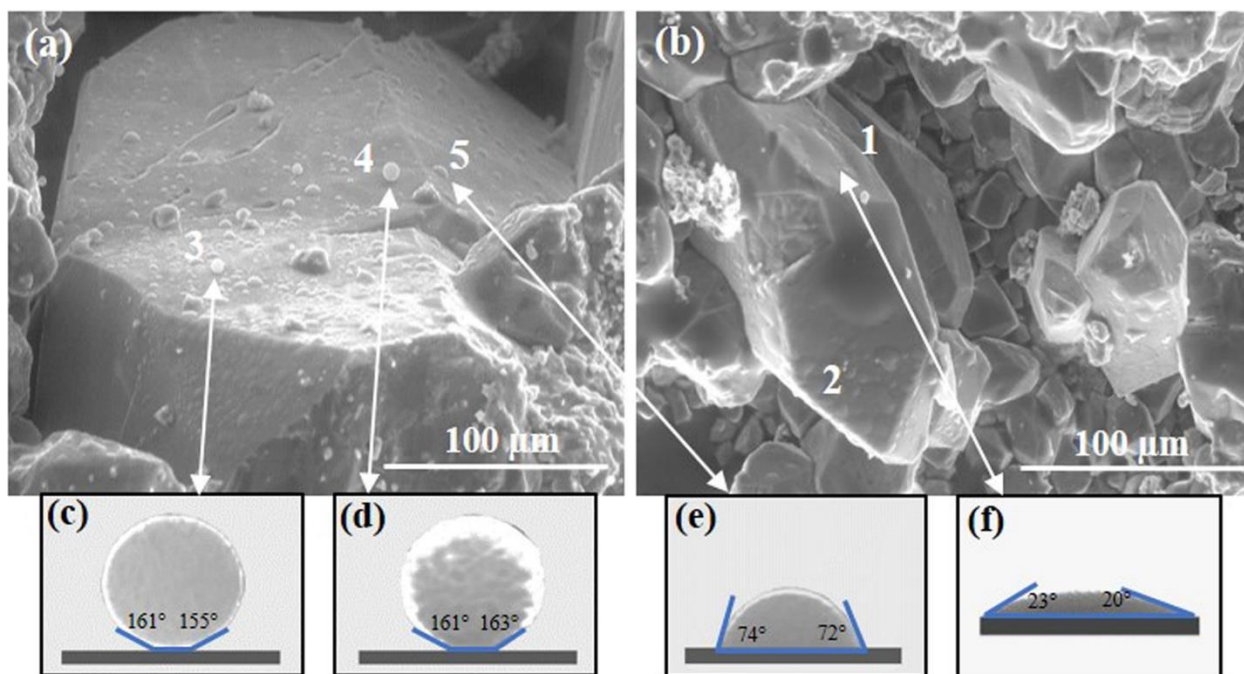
(a,b) ESEM images with formed water droplets on carbonate surface after solvent extraction; (c–f) Extracted droplet profiles from the picture (a,b) respectively with calculated contact angles; (c–e) droplet images represent mixed wetting properties of carbonate surface with two different types of contact angle – $160 \pm 3^\circ$ and $73 \pm 1^\circ$; (f) image refers to hydrophilic wetting properties with the average contact angle of $22 \pm 2^\circ$. X-ray analyses were performed in points 3, 4, 5 in (a) and 1, 2 in (b) ESEM images. The sample temperature and chamber pressure were kept around 0°C and 850 Pa , respectively.
